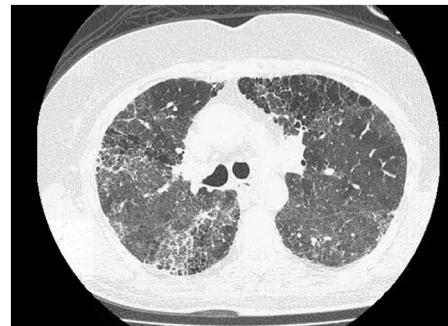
Chest computed tomography scan before interstitial lung disease exacerbation. Reticular opacities associated with traction bronchiectasis, architectural distortion and honeycombing can be noted.
